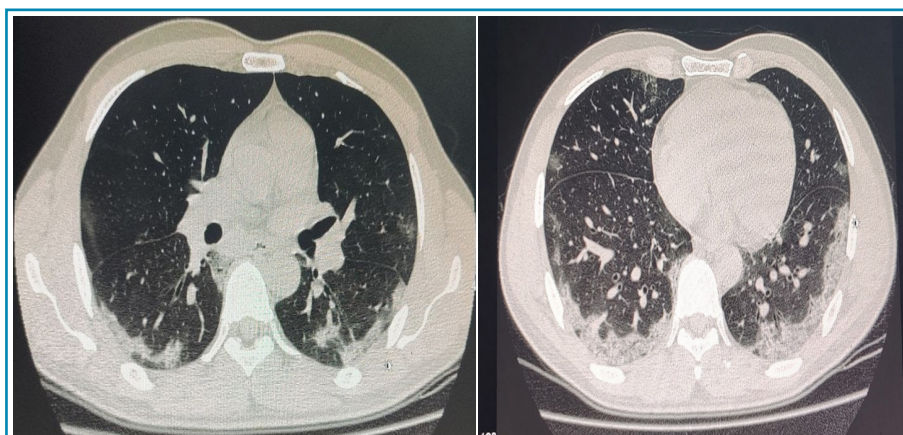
HRCT axial view showing bilateral peripheral sub pleural ground glass opacities (Severity Score: Mild; involving 5-25% of bilateral lower lobes; < 5% right middle lobe)
